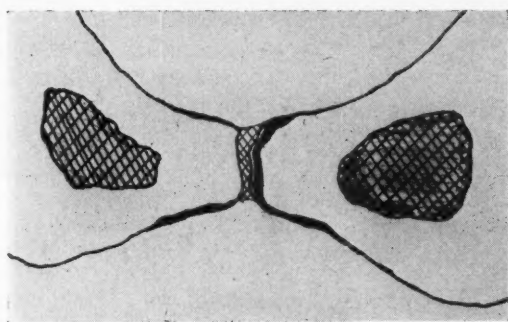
B. C. (C.S.H. No. 9176) Superimposed shadowgraphs of x-rays of symphysis before and after relaxin treatment. Cross-hatch is pretreatment separation, heavy black line is increased separation after treatment.
